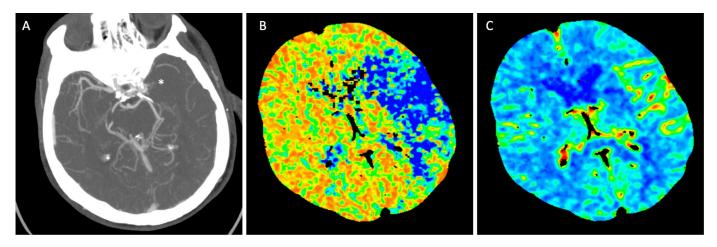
Case #2 (A) Axial section of a maximum intensity projection reconstruction CT angiography of intracranial circulation demonstrating the occlusion of the M1 segment of left ACM (asterisk). (B) CT perfusion scan maps showing increased mean transit time and (C) increased cerebral blood volume in the left ACM territory demonstrating ischemic penumbra.
